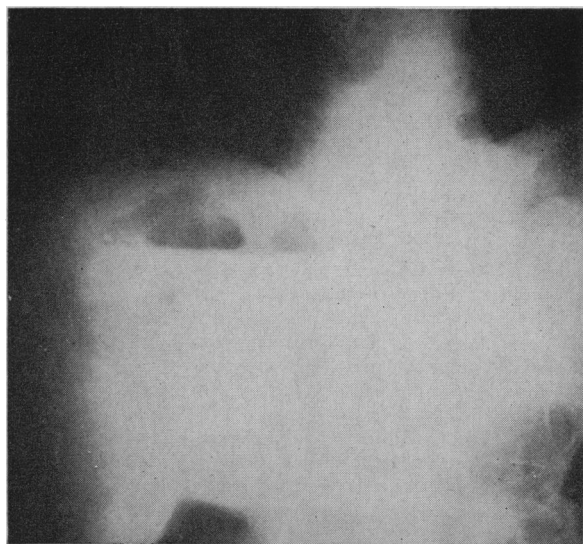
Roentgenogram of the abdomen, showing area of decreased density with fluid level, in a case of abscess of the liver due to *Clostridium welchii*.
